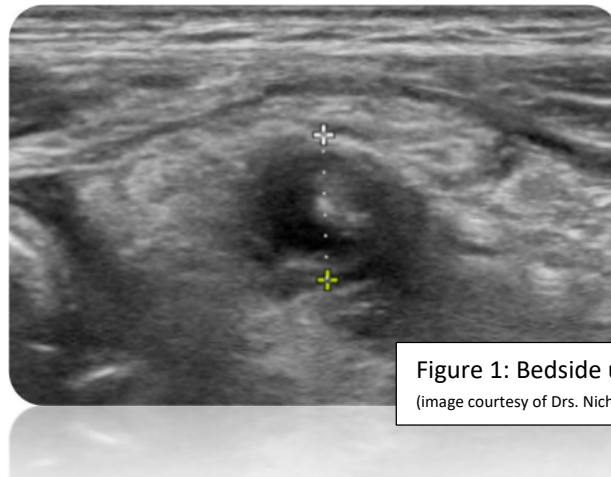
Bedside ultrasound of right lower quadrant
